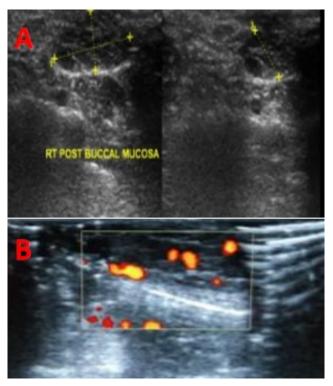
A & B: Ultrasonography revealing hypoechoic, soft tissue masses with a venous type of vascularity.
